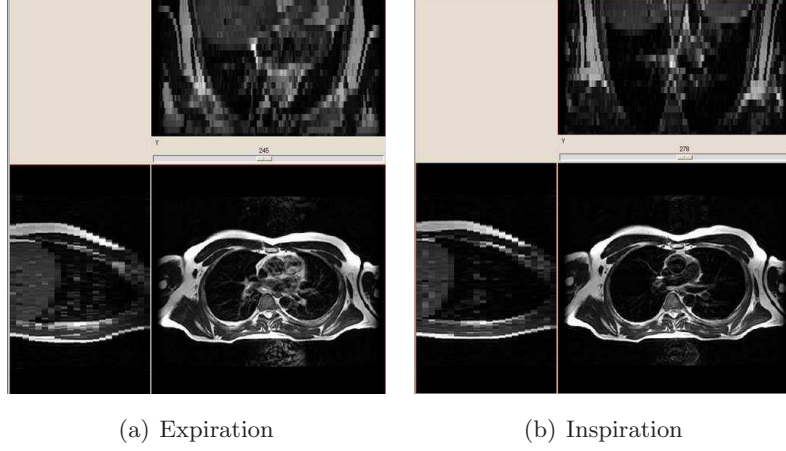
Two MRI images from a volunteer (taken at inspiration and expiration) were non-rigidly registered to create a real and known respiratory motion deformation.
